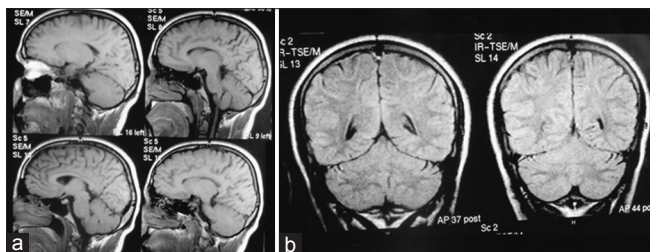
Sagittal (a) and coronal (b) magnetic resonance imaging section of the patient with no intracranial abnormality
